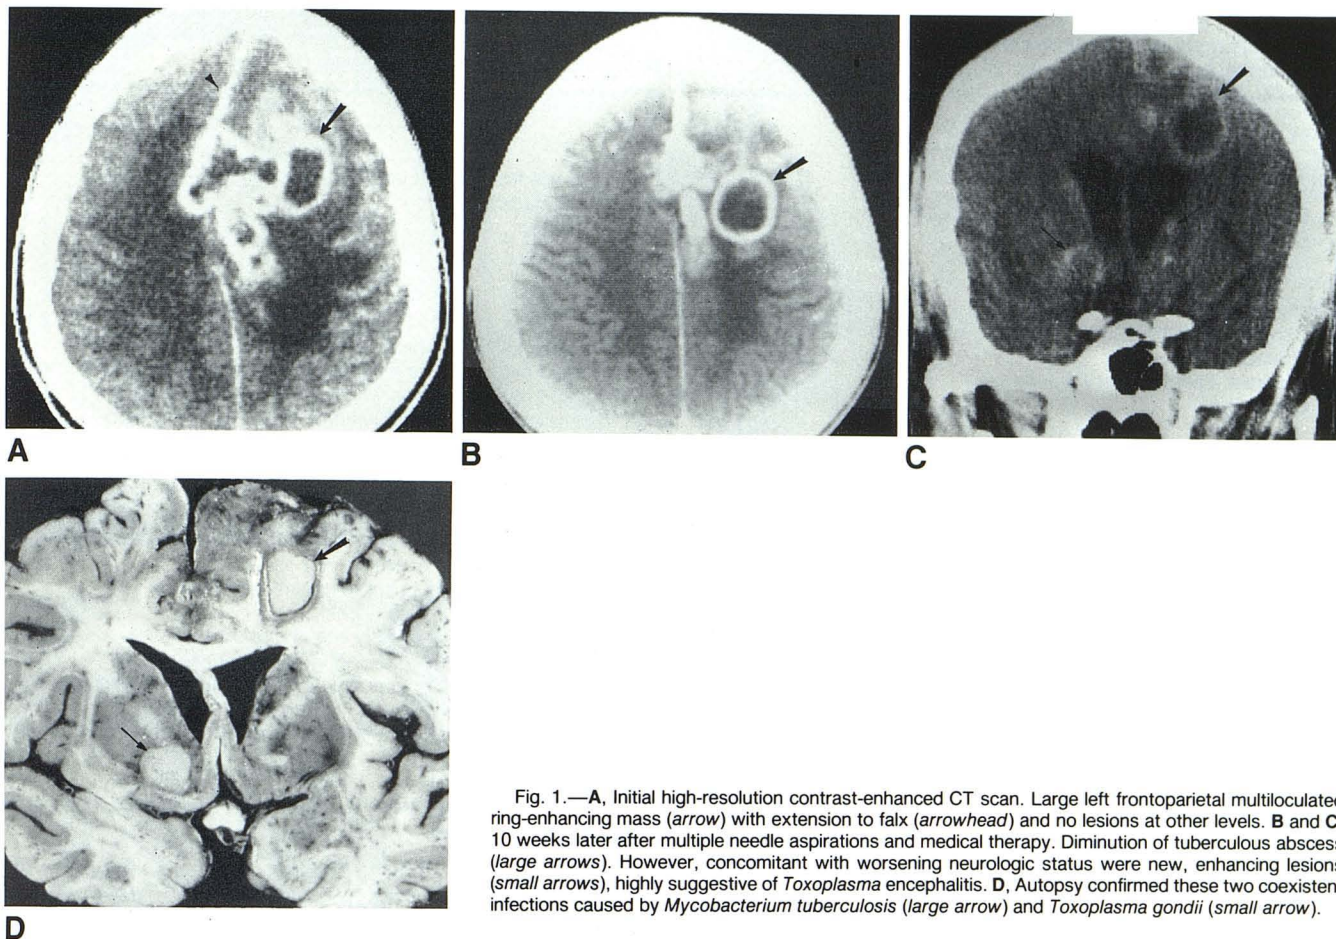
A, Initial high-resolution contrast-enhanced CT scan. Large left frontoparietal multiloculated ring-enhancing mass (arrow) with extension to falx (arrowhead) and no lesions at other levels. B and C, 10 weeks later after multiple needle aspirations and medical therapy. Diminution of tuberculous abscess (large arrows). However, concomitant with worsening neurologic status were new, enhancing lesions (small arrows), highly suggestive of *Toxoplasma* encephalitis. D, Autopsy confirmed these two coexistent infections caused by *Mycobacterium tuberculosis* (large arrow) and *Toxoplasma gondii* (small arrow).
